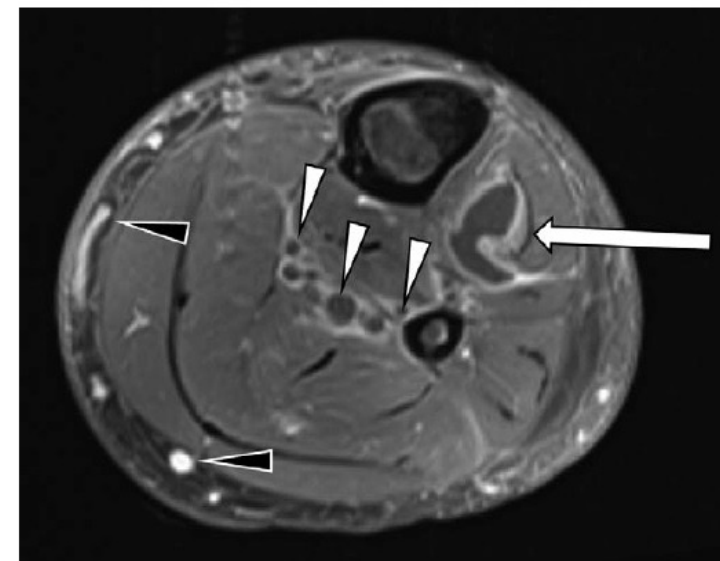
Patient 1 at 3 days after admission. Axial contrast-enhanced T1-weighted MRI with fat suppression of the proximal left lower thigh. Large arrow: abscess formation with circular contrast enhancement in the ventral compartment. Small arrows: thrombosis of deep veins. Small black arrows: subcutaneous veins with contrast. MRI = magnetic resonance imaging.
